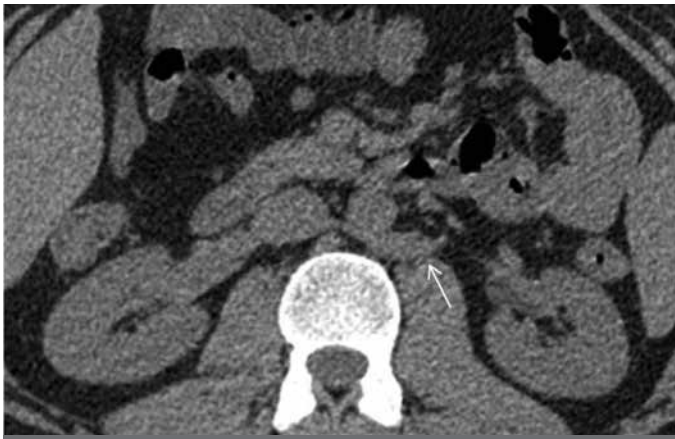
Axial noncontrast CT image of a 40-year-old male with sclerosing mesenteritis (panniculitis) shows heterogeneity of the central mesenteric fat with small lymph nodes within the inflamed area (arrow)
